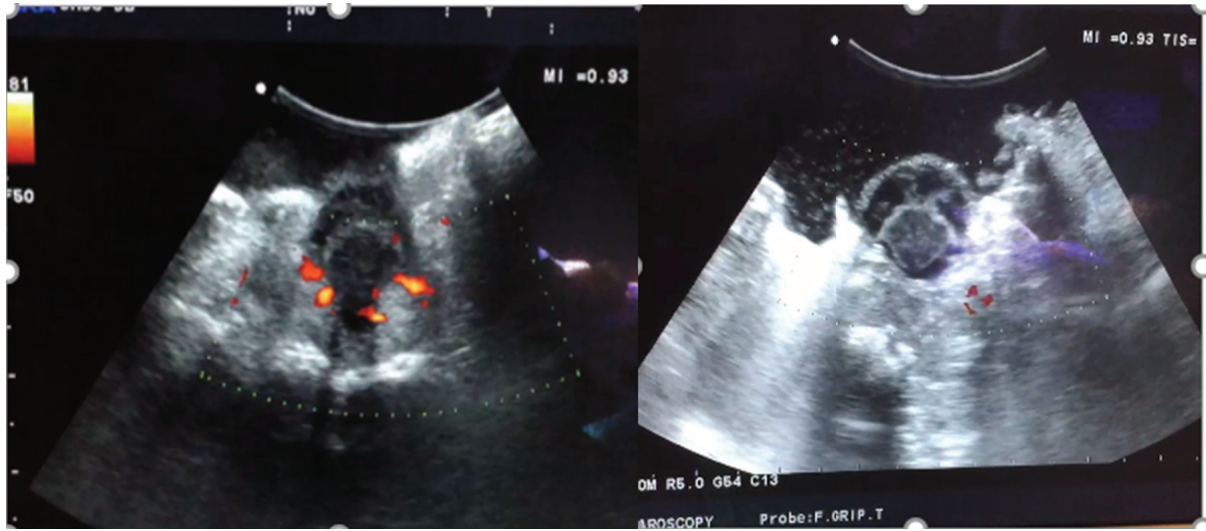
Patient 2: Doppler ultrasound images – Doppler ultrasound images show increased blood flow prior to tumour cauterization relative to images acquired post-cauterization. High frequency micro-ultrasound was not available.
